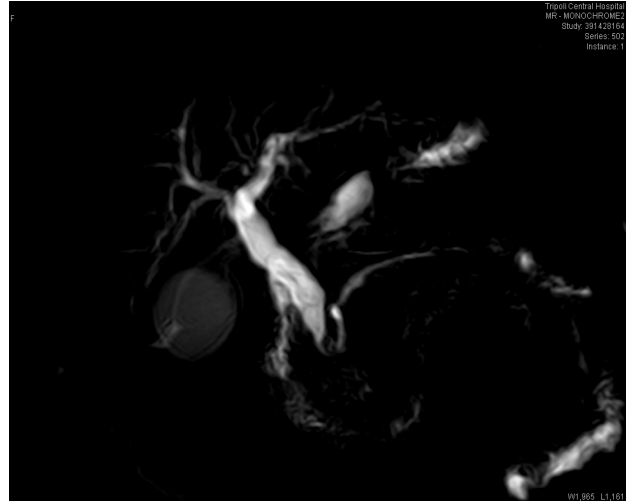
(A): 3D MIP MRI images shows benign CBD stricture.
